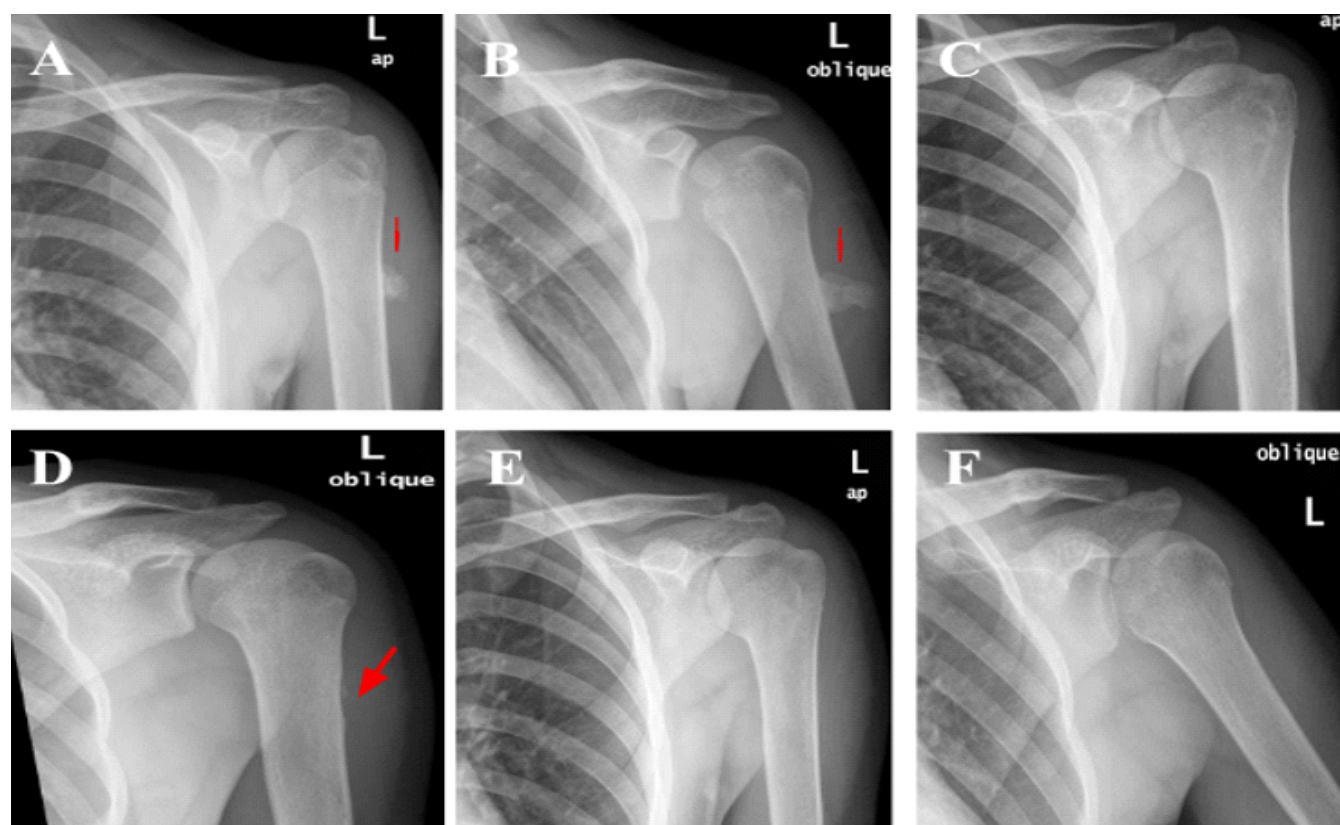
Serial anteroposterior and oblique radiographs of the left proximal humerus following trauma demonstrated progressive regression and complete resolution of a solitary pedunculated osteochondroma. (a and b) Radiographs at 2 weeks post-injury showed a pedunculated osteochondroma at the proximal third of the humerus with associated callus formation over the fracture stump. (c and d) Follow-up radiographs at 14 months demonstrated almost complete regression of the lesion with only a small bony remnant and scalloping of the posterolateral cortex at the site of the lesion. (e and f) Radiographs at 18 months showed complete resolution of the osteochondroma with full remodeling of the bone.
